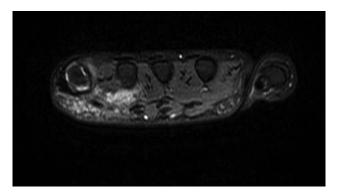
Contrast T2-weighted MRI axial view of the left-hand ill-defined heterogeneous soft-tissue mass.
